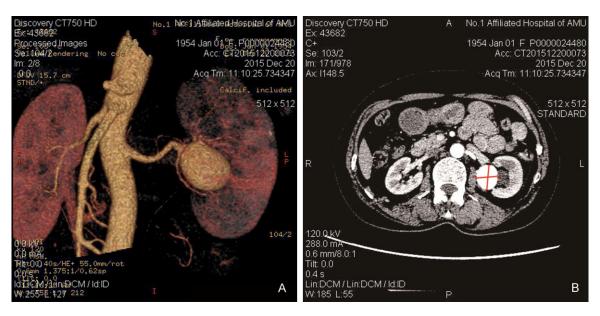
A: Preoperative computed tomography angiography showed a 3.12×2.23 cm aneurismal dilatation at the trunk of the left renal artery adjacent to the renal hilum. B: Preoperative contrast enhanced computed tomography demonstrated the size of left RAA was 3.0×2.2 cm.
